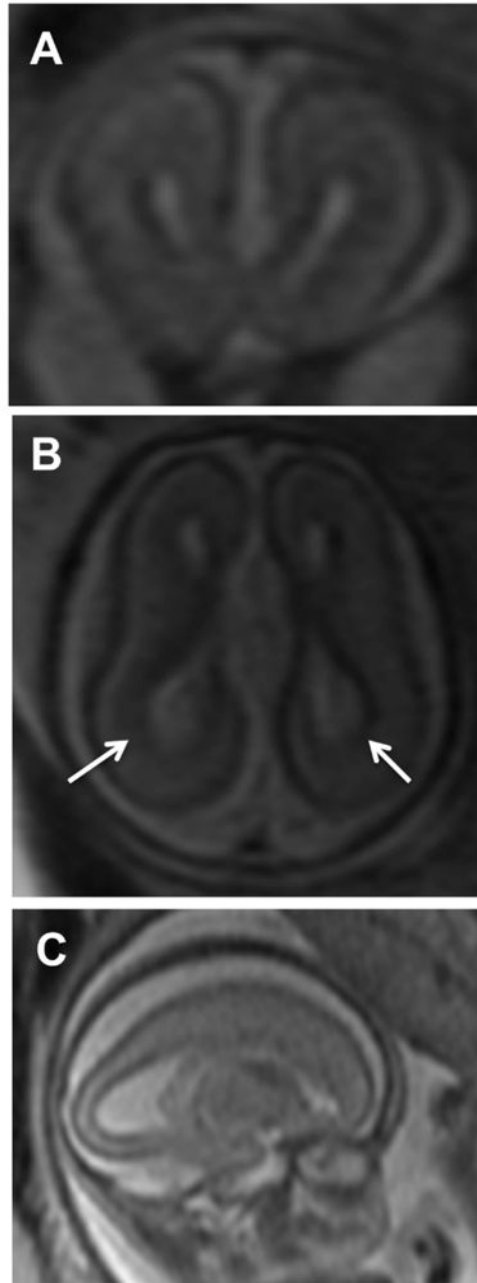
IMAGES. A-Coronal, B-Axial and C-Parasagittal images from a fetal MRI conducted at 22 wk and 2 days gestation showing enlarged lateral ventricles (more posteriorly (white arrows); colpocephaly) and agenesis of the corpus callosum
